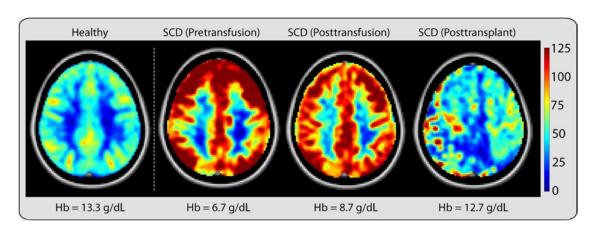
Changes in cerebral blood flow before and after blood transfusions and haplo-BMT with thiotepa and PTCy in a patient with SCD. Quantitative cerebral blood flow (CBF) maps show that CBF increases to maintain sufficient oxygen and glucose supply in people with anemia. The healthy image depicts the brain of an African American woman (aged 32 years, HbAA) with a hemoglobin concentration of 12.6 g/dL and a cortical CBF (assessed by arterial spin labeling magnetic resonance imaging) of 40 to 60 mL per 100 g per min. The SCD images are from an African American man with SCD (aged 34 years, hemoglobin SS); pretransfusion, his CBF was elevated to offset reduced oxygen content. Following blood transfusion, which increased the total hemoglobin and reduced the proportion of hemoglobin S, the CBF decreased but remained elevated relative to that in nonanemic individuals. After haploidentical BMT (haplo-BMT) with thiotepa and PTCy, both anemia and HbS were eliminated, and CBF approached that of a healthy control (HbAA). CBF heterogeneity was still present in this patient due to underlying moyamoya vasculopathy. Hb, hemoglobin concentration. (From Lancet Neurol. 2021 May;20(5):398-408.)
